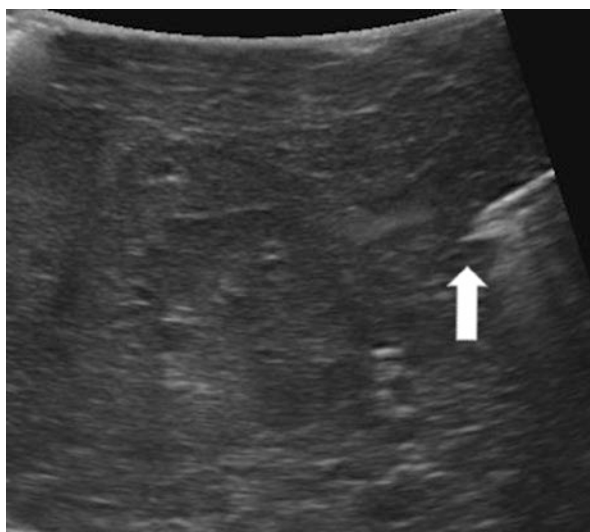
Laparoscopic ultrasonography demonstrating the direction of needle (*arrow*)
